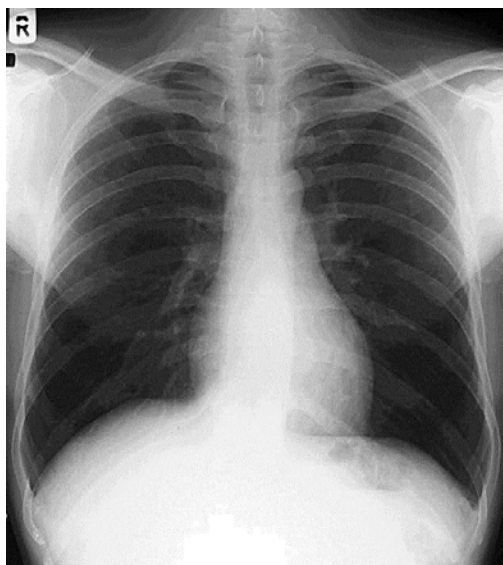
Chest radiograph. Frontal view
